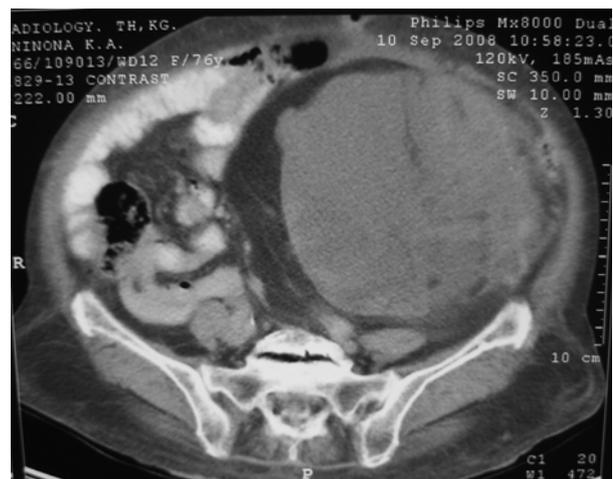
CT images showing the angiomyolipoma.
